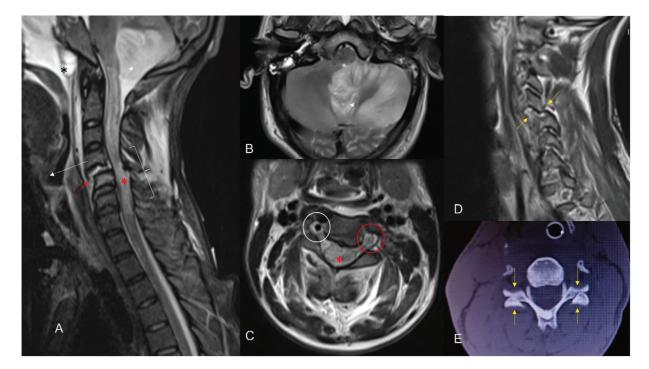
The sagittal short tau inversion recovery (STIR) (A) magnetic resonance (MR) image reveals a grade 2 anterior listhesis of the C4 over C5 vertebral body (long white arrow), indicating a translational injury. The spinal cord is compressed and shows significant edema (red asterisk), along with a discoligamentous complex injury (red arrow and white bracket). The axial T2-weighted (T2W) MR image (B) at the posterior fossa level demonstrates infarcts (arrow) in the left cerebellar hemisphere, causing a mass effect. (C) Another axial T2W MR image at the C5 level shows a loss of flow signal in the left vertebral artery (encircled in red) compared with the right side (encircled in white), indicating thrombosis responsible for posterior circulation stroke in this patient. The sagittal para-midline MR image (D) and the axial bone window computed tomography (CT) image (E) show locked bilateral facet joints (paired yellow arrows) with CT specifically displaying a "reversed hamburger sign."
